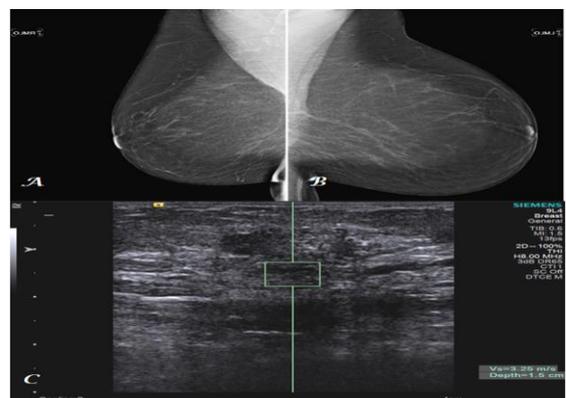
X-ray mammogram of bilateral breasts showing both MLO (A) & CC (B) views depict no obvious abnormality. B-mode scan (C) right breast shows presence of a hypoechoic lesion which on subsequent VTI (D) shows a relatively soft lesion depicted as grey colour in the area of the lesion suggesting a softer mass indicating a benign pathology. On subsequent VTTQ (E) shear wave velocity was seen to be 2.6 m/sec which further supports that the lesion is relatively soft suggesting a benign pathology.
